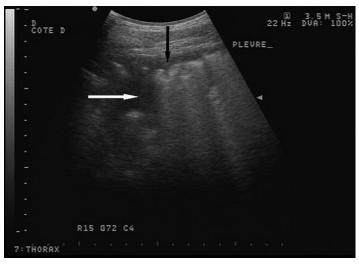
Ultrasonographic evaluation of the right caudoventral thoracic cavity of a 2-year-old Holstein heifer with *Mannheimia haemolytica* bronchopleuropneumonia. A 3.5-mHz curvilinear probe was used to obtained this picture. Fluids can be seen in the thoracic cavity (*black arrow*). The visceral pleura is irregular and an abscess is forming in the lungs (*white arrow*). (*Courtesy of* Dr Marie Babkine, University of Montréal, St-Hyacinthe, Québec, Canada.)
